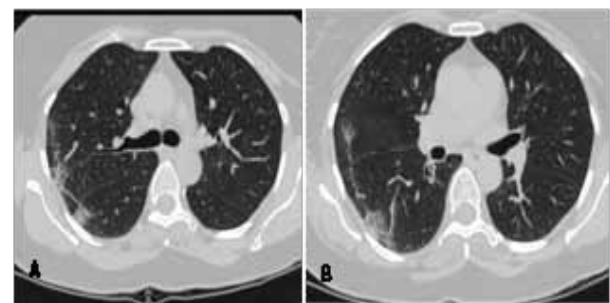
(A,B,C and D): Non-contrast axial chest CT images in the lung window setting of a 50-year old male and 68-year female COVID-19 positive patient, obtained 7 days after symptom onset, at the carinal (a), subcarinal (b,d), mid-basal (c) levels showing bilateral, confluent ground glass opacities with pronounced peripheral distribution with perilesional vessel enlargement (c,d).
